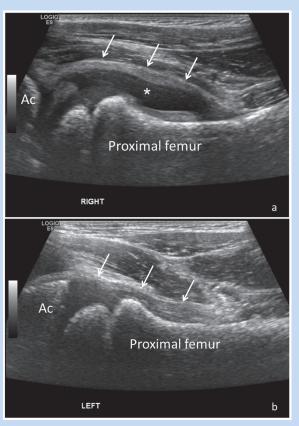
Sonographic evaluation of the hips in a pediatric patient with right hip pain and clinical suspicion for juvenile inflammatory arthritis. (a) Longitudinal ultrasound (US) image of the right hip reveals distension of the joint capsule (white arrows) by a large joint effusion (*), in keeping with synovitis. (b) Comparative longitudinal US of the left hip demonstrates a normal hip joint with a decompressed joint capsule (arrows). Ac, acetabulum.
